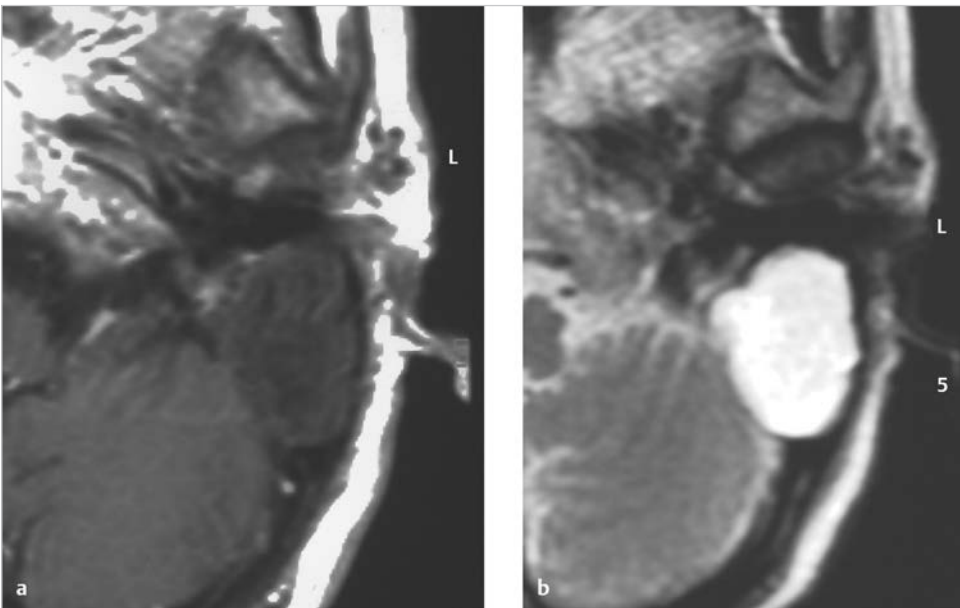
The lesion shows low signal in T1-weighted image (a) of MRI, and high in T2-weighted image (b), corresponding to cholesteatoma.
